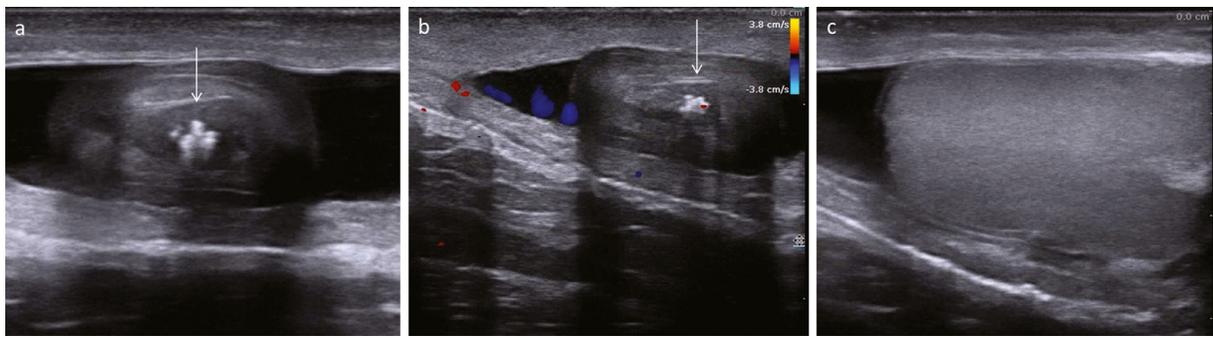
Ultrasound images of a hypotrophic testis with "burned out tumour" lesion (arrows) reveal an area of heterogeneous echotexture (scar tissue) and centrally located calcifications. (a) B-Mode, longitudinal projection. (b) Color Doppler image, longitudinal projection. (c) Ultrasound image of normal contralateral testis, transverse projection.
